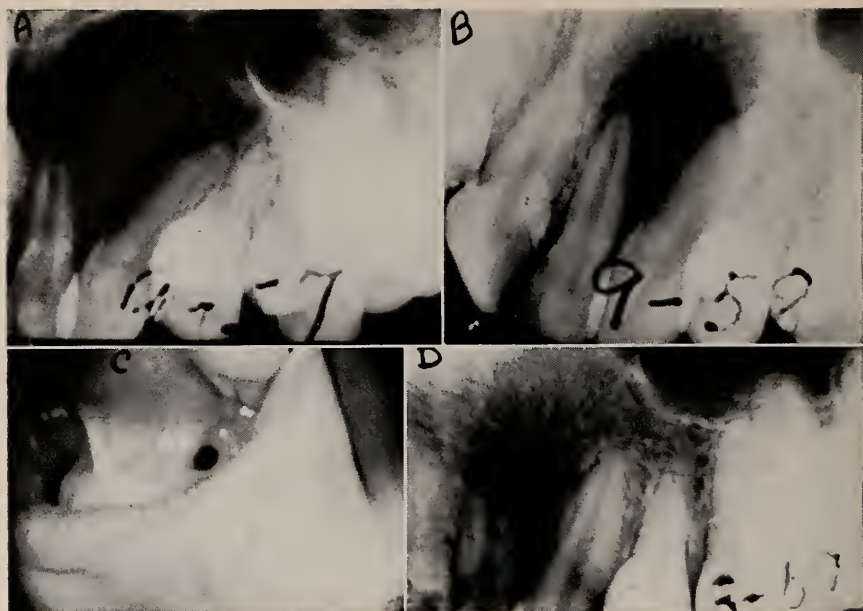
Case 2. Globulomaxillary cyst. 3. Note area of extensive rarefaction in initial diagnostic x-ray. B. One year following initial treatment showing reduction in size of area. C. Shows surgical window in which obturator was placed. D. Note complete osseous regeneration.
